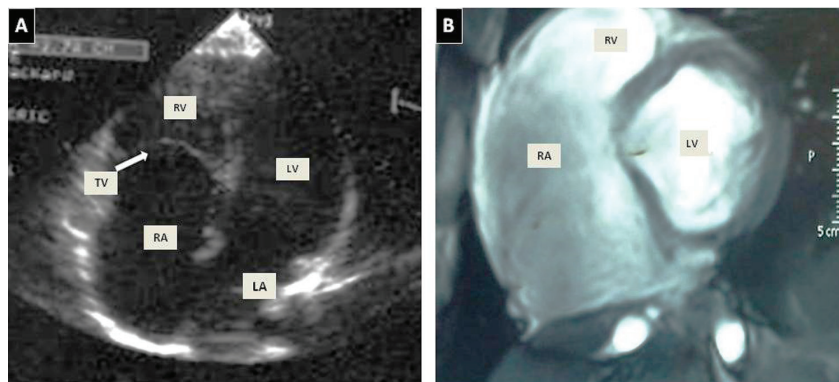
Images showing the A) transthoracic echocardiogram of the low implantation of the TV and RV atrialization was visualized in a 4-chamber view. B) Vectographic image using MR showed extensive RA dilatation (53 x 103 mm) with atrialization of the RV inflow tract and showed the TV with abnormal apical implantation of the septal leaflet (31 mm). MR - magnetic resonance, RA - right atrium, TV - tricuspid valve, LA - left atrium, RV - right ventricle, LV - left ventricle.
